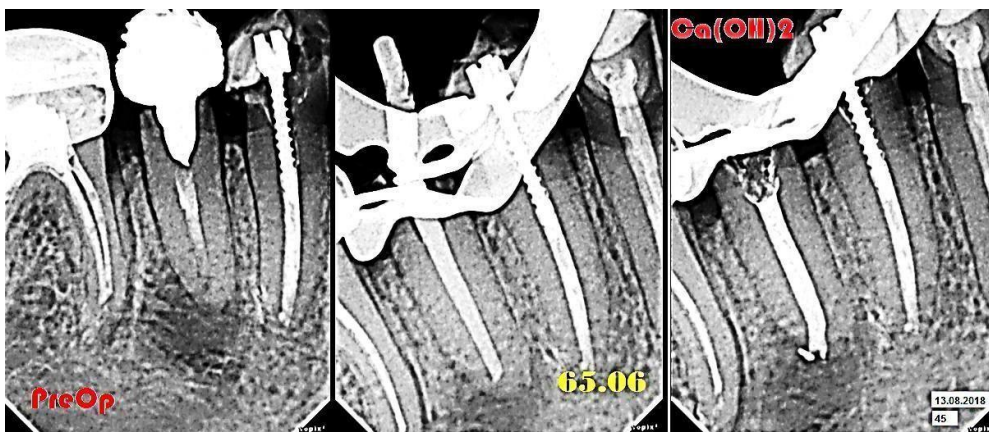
Radiographs of tooth 45: initial situation (a); image with a calibrated gutta-percha pin of 06 taper (b); image with a temporary calcium-containing material in the root canal (c).
